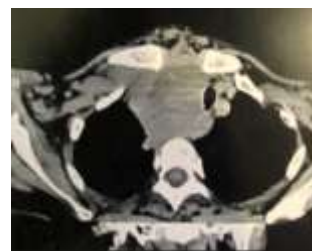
Computed tomography scan of the neck (axial section) showed a large right lobe retrosternal goiter and narrowing of the trachea.
